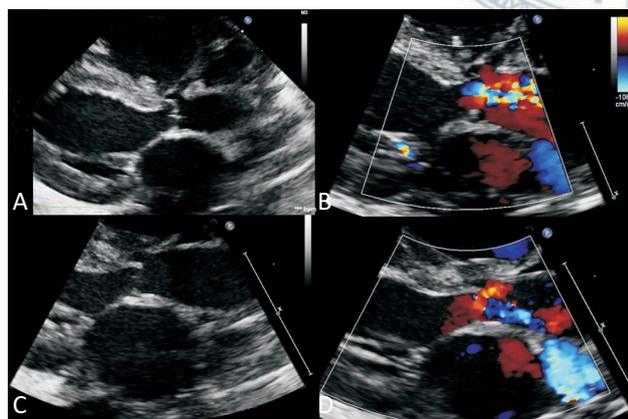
Echocardiogram showed thick aortic valve with a small valve opening on long axis view (A) and color Doppler (B). After balloon aortic valvuloplasty, improvement of aortic valve opening (C) and color Doppler through aortic valve (D) was seen.
